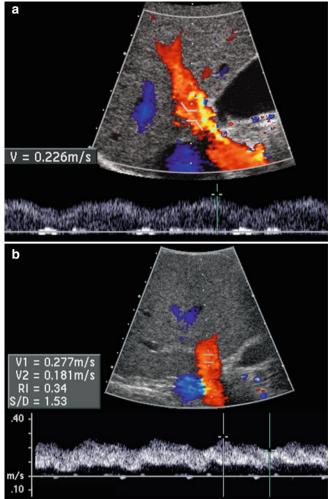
Portal vein waveform. (a) Color and spectral Doppler sonogram of the main portal vein, demonstrating continuous, antegrade, mildly undulating flow into the liver with a peak velocity of 22.6 cm/s. (b) Portal Doppler waveform showing mild pulsatility with the lowest velocity (18.1 cm/s) measuring >0.5 times the peak velocity (27.7 cm/s)
